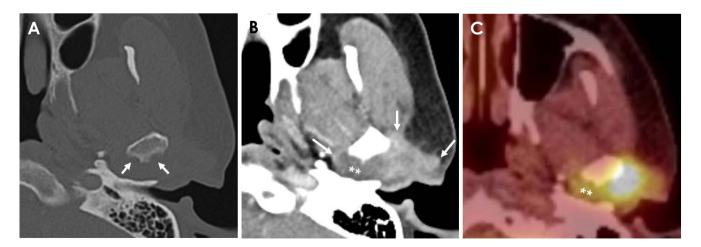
An axial bone setting computed tomographic image (A), taken 1 month after biopsy shows extensive erosion (arrows) on the posterior surface of the condyle. An axial contrast-enhanced computed tomographic image (B) reveals a heterogeneously enhancing mass with a locally non-enhancing area (asterisk). Positron emission tomography (C) taken 2 weeks later shows a hypermetabolic-signal lesion with less uptake (asterisk) in the medial part.
